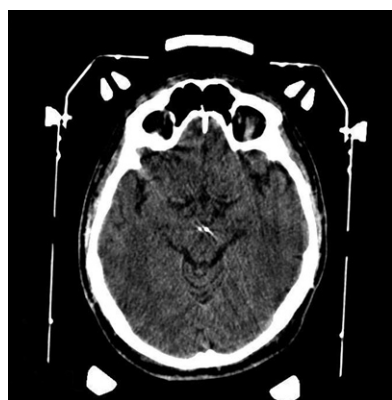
Postoperative computed tomography scan showing the electrode tips at the level of the posterior hypothalamic region, bilaterally.
